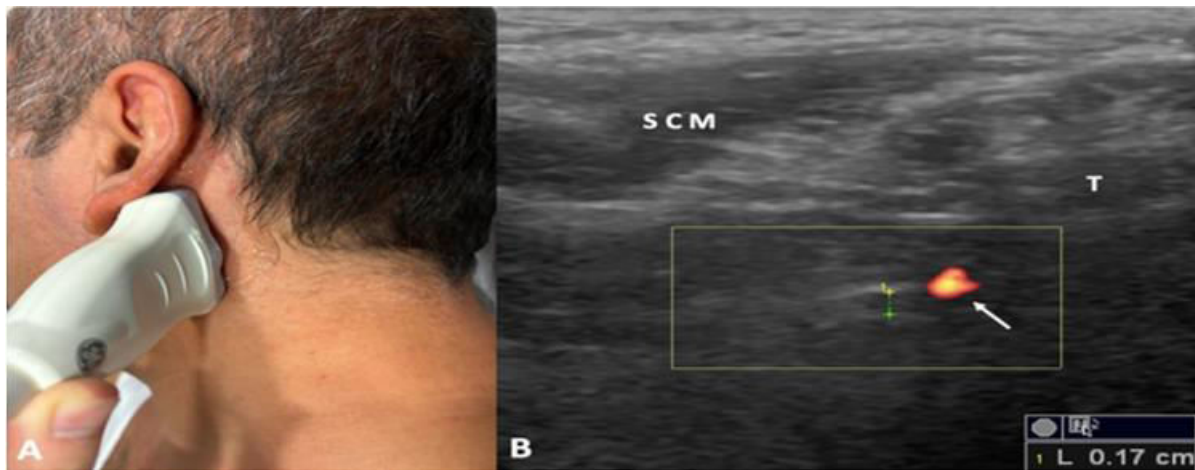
Patient and probe positioning during the ultrasound examination (A). Measurement of the facial nerve main trunk (longitudinal view) as it exits through the stylomastoid foramina (B). T: temporal bone, SCM: sternocleidomastoid muscle, arrow: posterior auricular artery, adopted from Abdulsalam et al. (2024).
